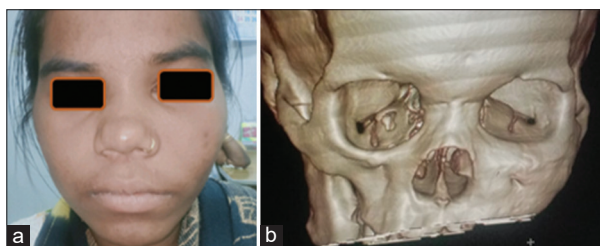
(a) Facial asymmetry, with volumetric enlargement in the zygomatic region and right maxilla, and obliteration of the nasolabial fold, (b) 3D computed tomography scan showing increased bony mass increase (Case 10)
